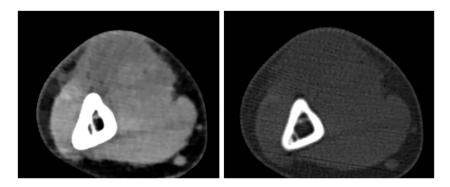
CT-scan of the elbow with axial views of soft tissue and bone windows showing the presence of a mass on the medial aspect with no abnormalities of the distal humerus.
